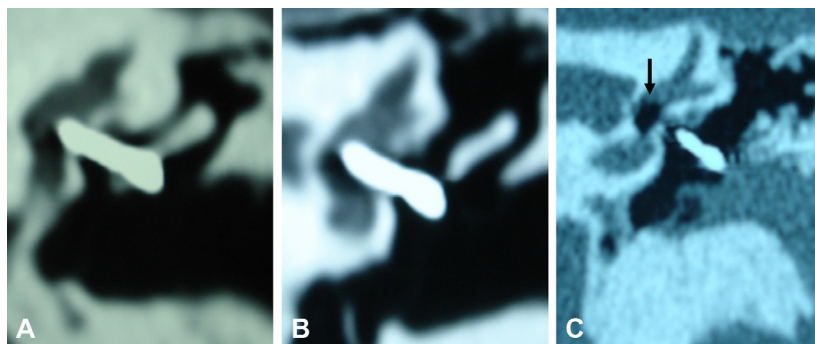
Position of a stapes prosthesis in otosclerosis. Coronal computed tomography scan obtained at the level of the oval window demonstrates a stapes prosthesis for otosclerosis. (A) The prosthesis is in the normal position extending from the long process of the incus to the oval window. (B) The prosthesis is abnormally extending through the oval window into the vestibule. (C) The prosthesis is extruded with an air gap between the prosthesis and the oval window and a pneumolabyrinth (arrow) in the vestibule.
